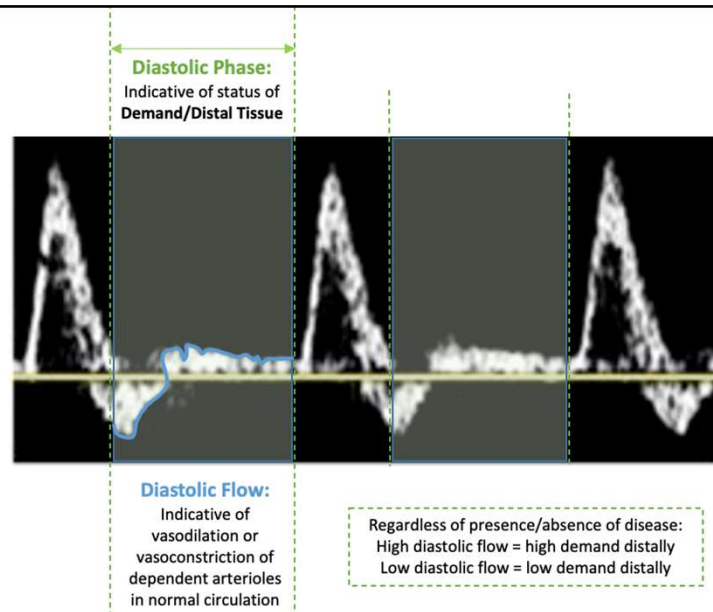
Diastolic phase of a spectral Doppler arterial waveform.<sup>6</sup>
